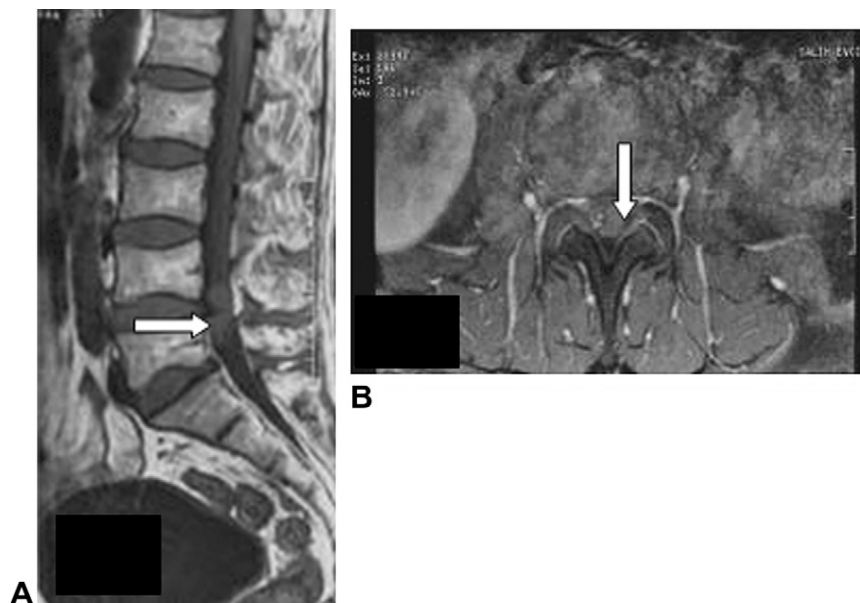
Lumbosacral MRI T1-weighted image in the sagittal plane (A) and axial plane (B) showing an intradural extramedullary mass located at the L4/5. The tumor is bilobulated.
